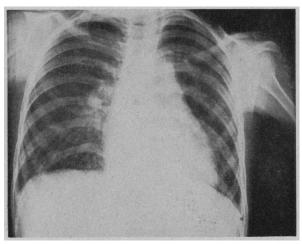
In a roentgenogram of the chest an increase in the size of the heart shadow, and congestion and engorgement of the pulmonary vessels were noted.
